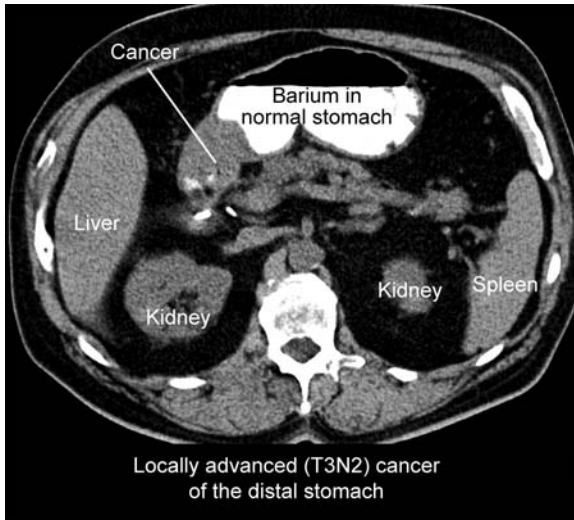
Antral cancer on CT scan with oral contrast
